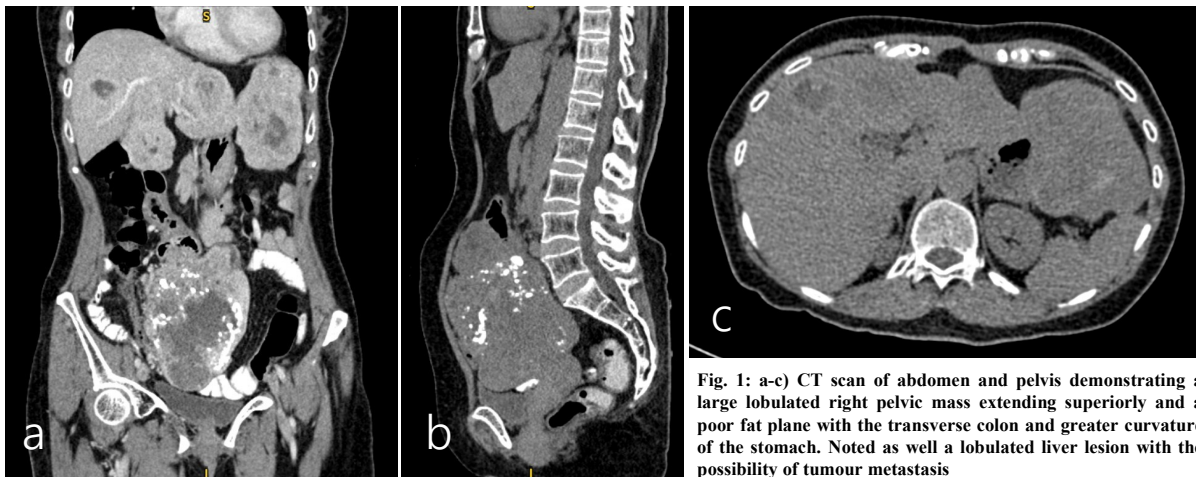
a-c) CT scan of abdomen and pelvis demonstrating a large lobulated right pelvic mass extending superiorly and a poor fat plane with the transverse colon and greater curvature of the stomach. Noted as well a lobulated liver lesion with the possibility of tumour metastasis
